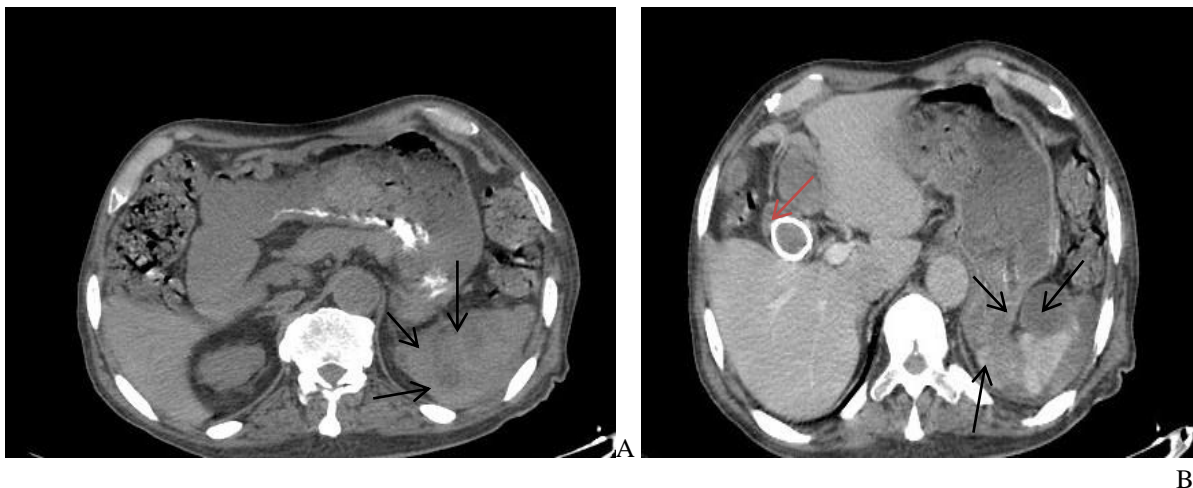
Axial section of an abdominal CT scan without (A) and following contrast injection in the portal phase with axial slices (B) demonstrating intrasplenic and subcapsular hypodense collections, some encapsulated and others not, with liquid density and thickened, enhanced wall, suggestive of splenic abscesses (arrow), Noted gallbladder stones (red arrow)
